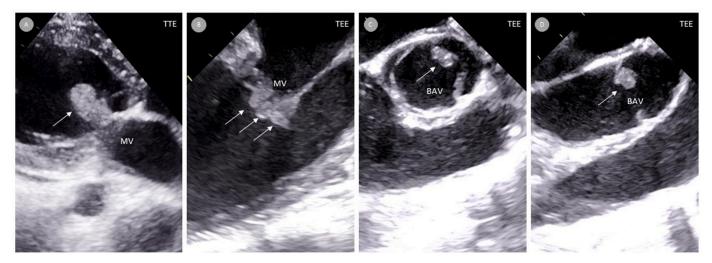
Echocardiography at admission: Large vegetations on mitral valve - MV (A and B) and small vegetation on bicuspid aortic valve - BAV (C and D). TTE - transthoracic echocardiography, TEE - transesophageal echocardiography.
